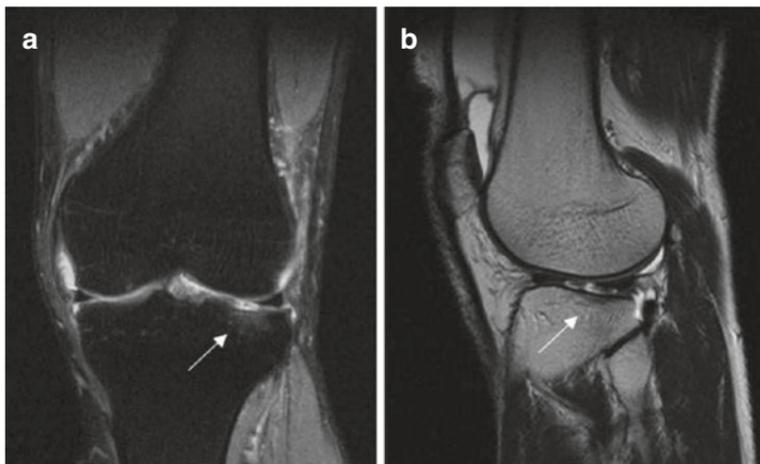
Preoperative coronal (a) and sagittal (b) magnetic resonance imaging demonstrating an isolated tibial plateau articular cartilage injury (white arrow) and associated bone edematous changes
